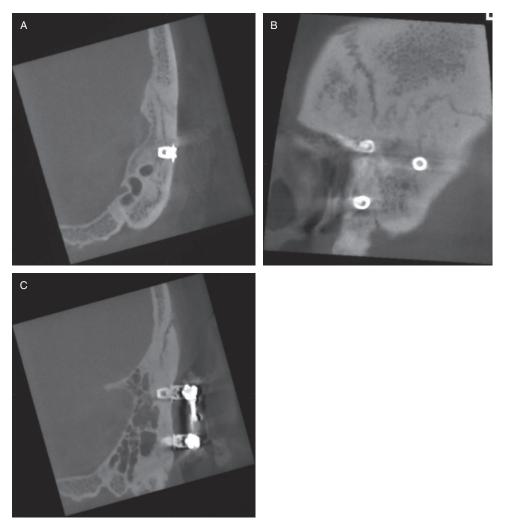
Cone beam computed tomography of the temporal bone showing *A*, the sleeping implant well integrated 20 years later, and with bone growing over the flange. *B*, The individual position of the three implants. *C*, Good anchorage of the loaded implants with minimal bone resorption under the flange.
